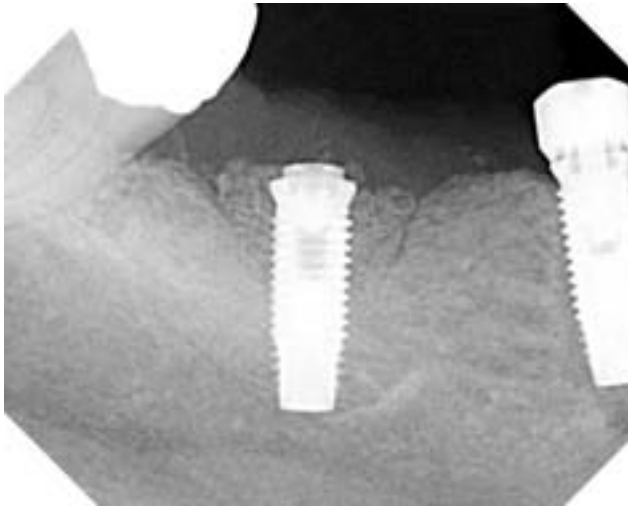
Radiograph of the bone graft on the day of the repair.
